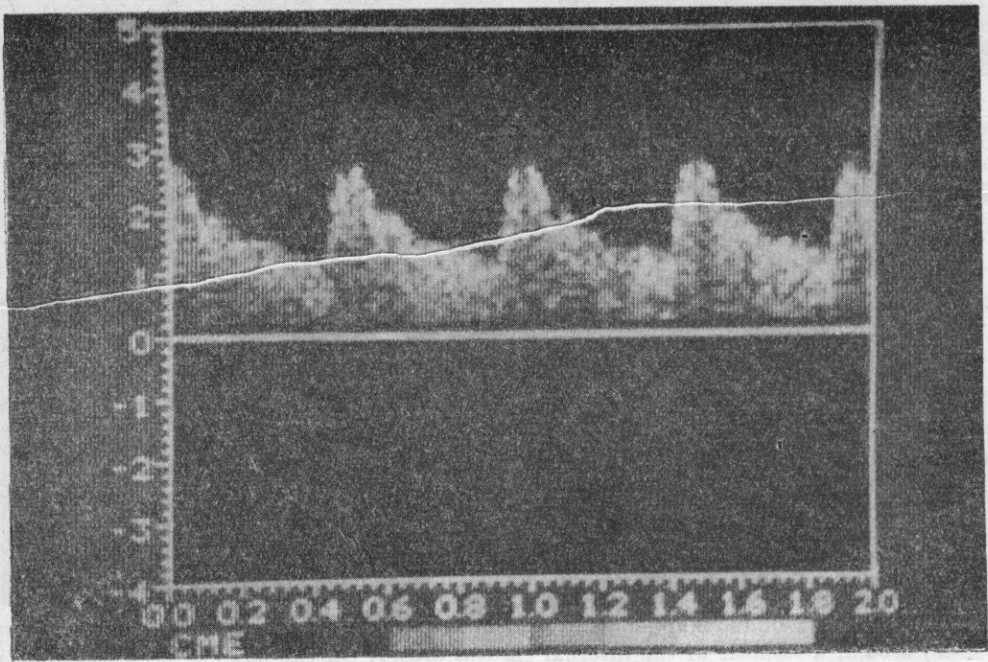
FSA of Doppler frequencies detected in the normal internal carotid artery. The abscissa presents a 2 second sweep. The ordinate is calibrated in kHz with velocities away from the transducer represented above the zero line. Laminar flow with a blunt profile can be concluded from this display because of the concentration of energies near the upper edge of the spectrum ( $f_{\max}$ ). The high diastole and downsloping contours of  $f_{\max}$  is characteristic of blood flow in arteries perfusing the brain
